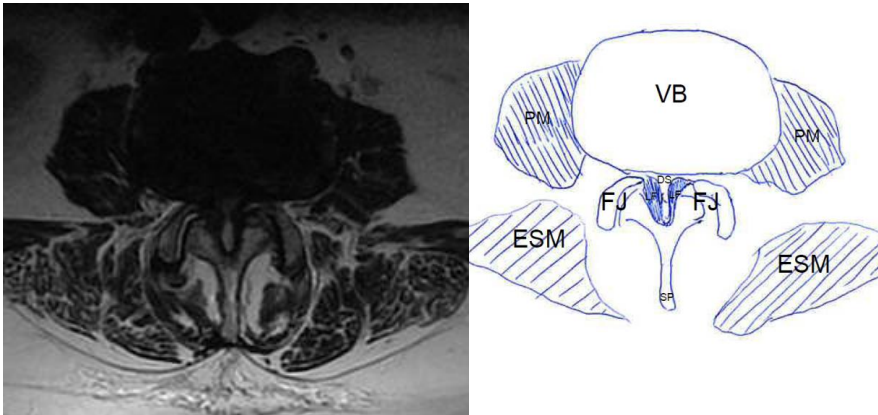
Transverse view (axial) of the lumbar spine in MRI in a stenotic segment; the area of the dural sac (DS) is restricted by thicker ligamentum flavum (LF) and osteophytes from the facet joints (FJ). VB = Vertebral body, D = Intervertebral disc, DS = Dural sac, SP = Spinous process, LF = Ligamentum flavum, F = Fascia, SF= Subcutaneous fat, FJ = Facet joint, PM = Psoas muscle, ESM = Erector spinae muscle.
